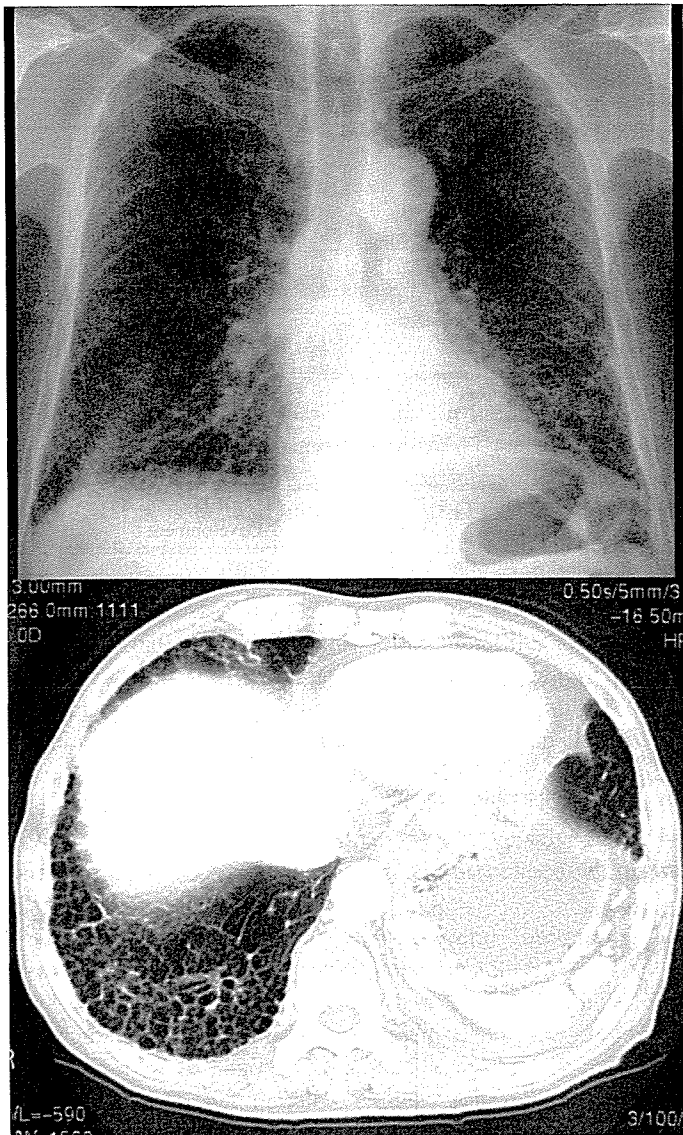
Severe interstitial shadow. An X-ray film of the chest shows bilateral reticular shadow. Reticular shadow is distributed in >30% of the bilateral lower lobes, with this being classified severe.
